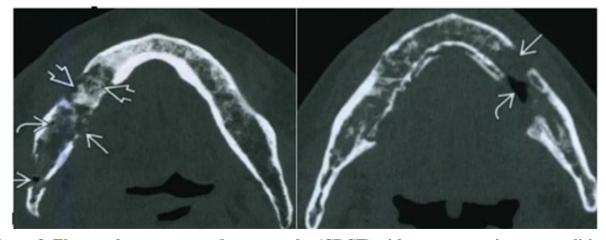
Electron beam computed tomography (CBCT) with posttraumatic osteomyelitis of the lower jaw on the left and right.
